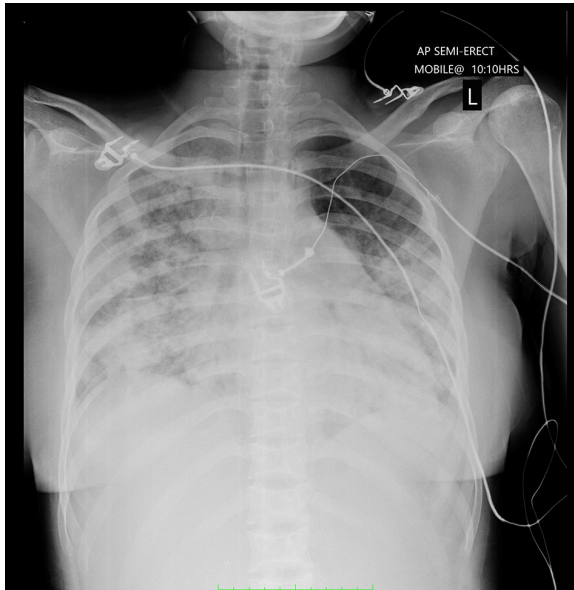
Chest radiograph of a patient with acute chest syndrome, showing bilateral consolidation in the bases
